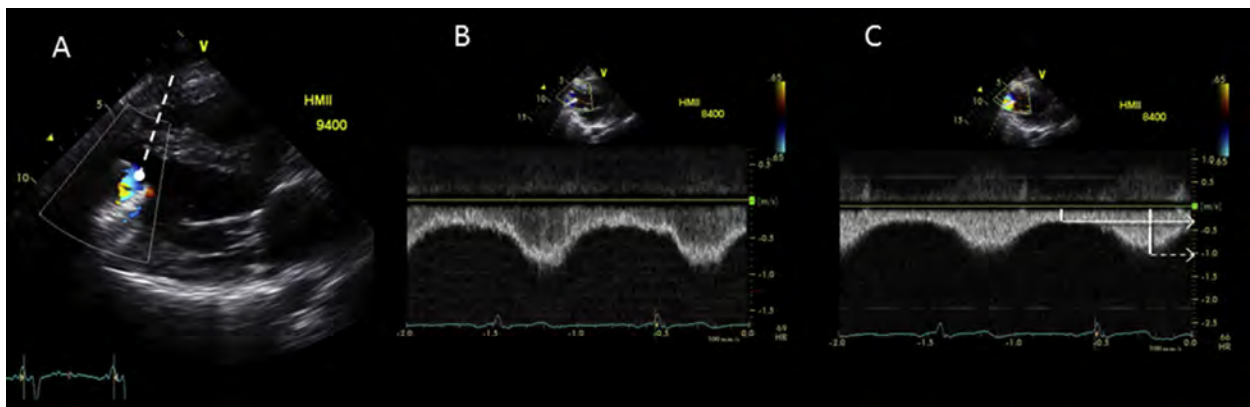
Normal HM-II inflow-cannula flow, which, in this case, required the use of a modified parasternal long-axis view for coaxial alignment of the sampling volume. (A) Color-flow Doppler with pulsed Doppler sample volume at the inflow cannula's inflow zone. See also [Video 27](#). The color-flow and pulsed spectral Doppler profiles (B) are consistent with laminar flow. (C) Peak systolic velocity = 1.0 m/s (dotted arrow) and nadir diastolic velocity = .3 m/s (solid arrow) as assessed by continuous-wave spectral Doppler. (Normal peak inflow velocities are typically <2 m/s).
